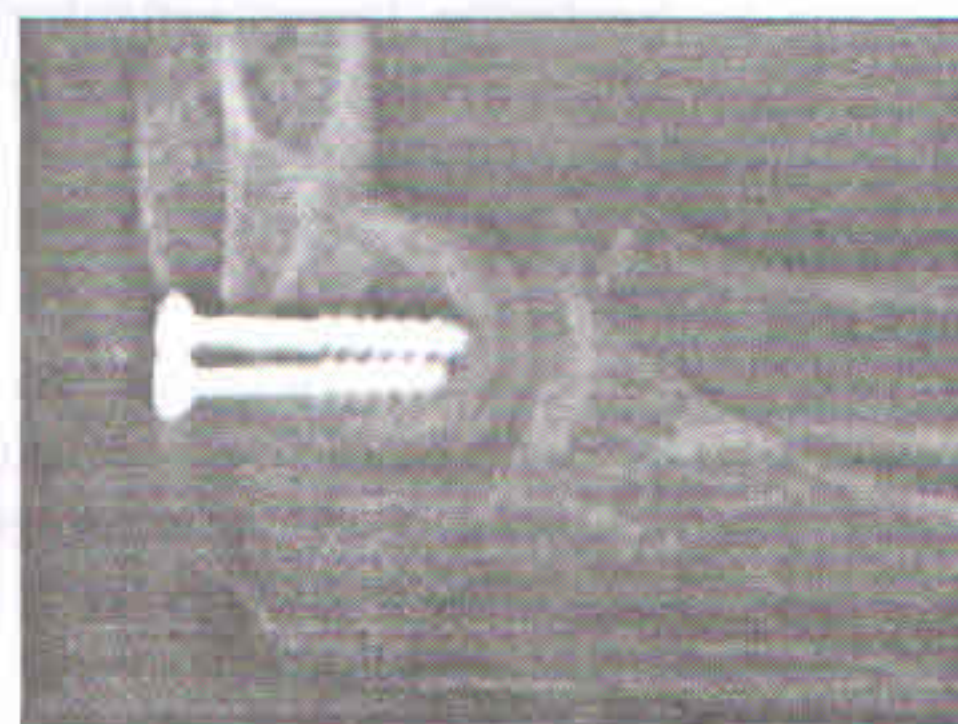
Figure (b) : Post operative X-Ray of the Case-1
